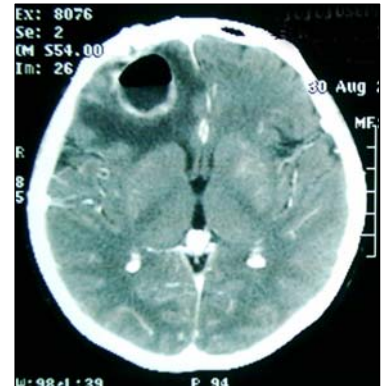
All control slides are CT contrasted phases, shown at the same cut; level of the third ventricle
